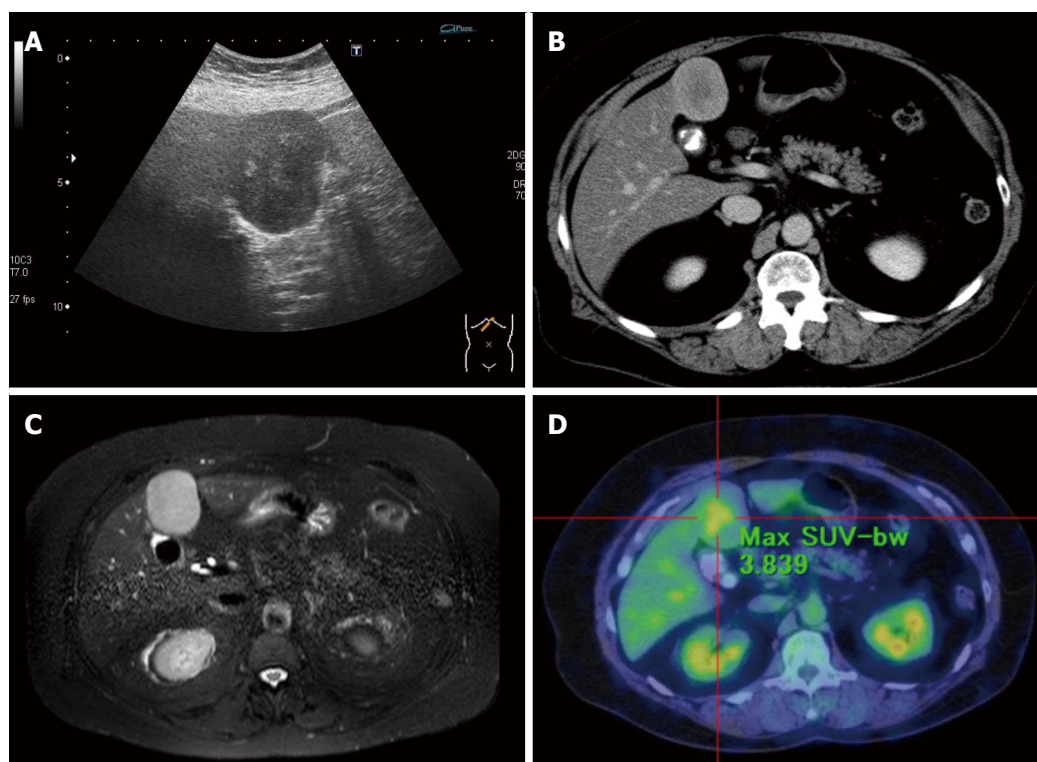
Evaluation of clinical findings. A: Ultrasonography of the liver showed a very-low-echoic smooth mass (60 mm × 40 mm) with a heterogeneous high-echoic region in the median section of the left lobe of the liver (Segment 4); B: Axial delayed phase CE-CT showed the lesion to be gradually enhanced heterogeneously; C: The lesion showed a hyperintense heterogeneous region on axial T2-weighted EOB-MRI; D: The lesion showed obvious metabolically active foci by 18-fluorodeoxyglucose-PET-CT evaluation, while other lesions were not detected.
